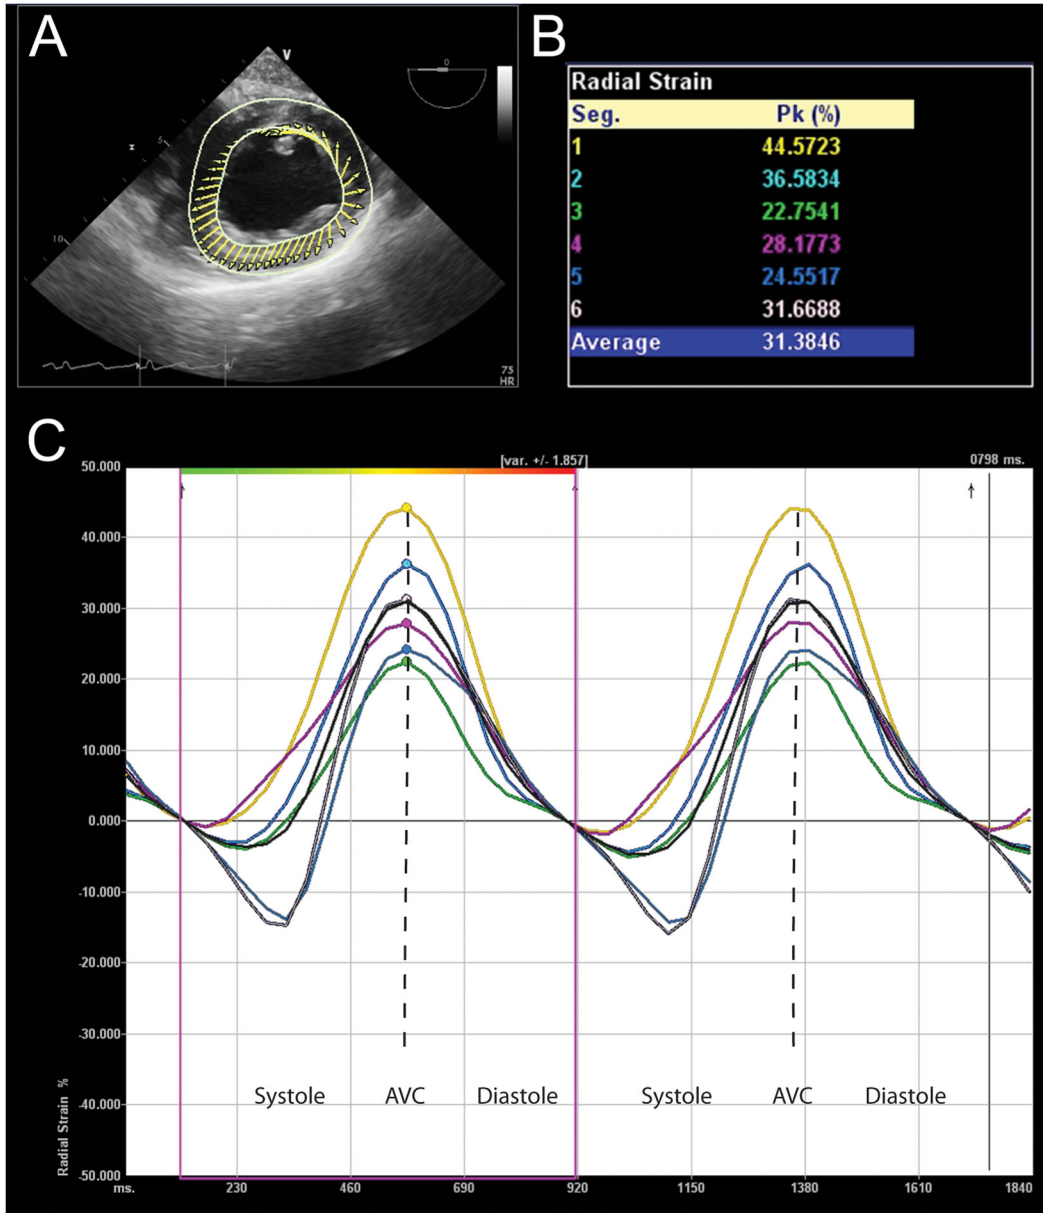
Radial strain analysis assessed with Velocity Vector Imaging (VVI) (Siemens Medical Solutions, Malvern, PA). (A) This transgastric midpapillary short-axis echocardiographic view depicts the LV, where the direction and relative length of arrows demonstrate direction and amplitude of myocardial velocities. (B) Peak radial strain for six myocardial segments is displayed in this table. (C) Strain curves of two cardiac cycles with time on the X-axis and percent radial strain on the Y-axis. These curves are color-coded to correspond to the myocardial segment described in similarly colored text in Panel B. Peak radial strain is identified with a similarly colored dots. Please note that radial strain is positive since the ventricle thickens in the radial direction.
